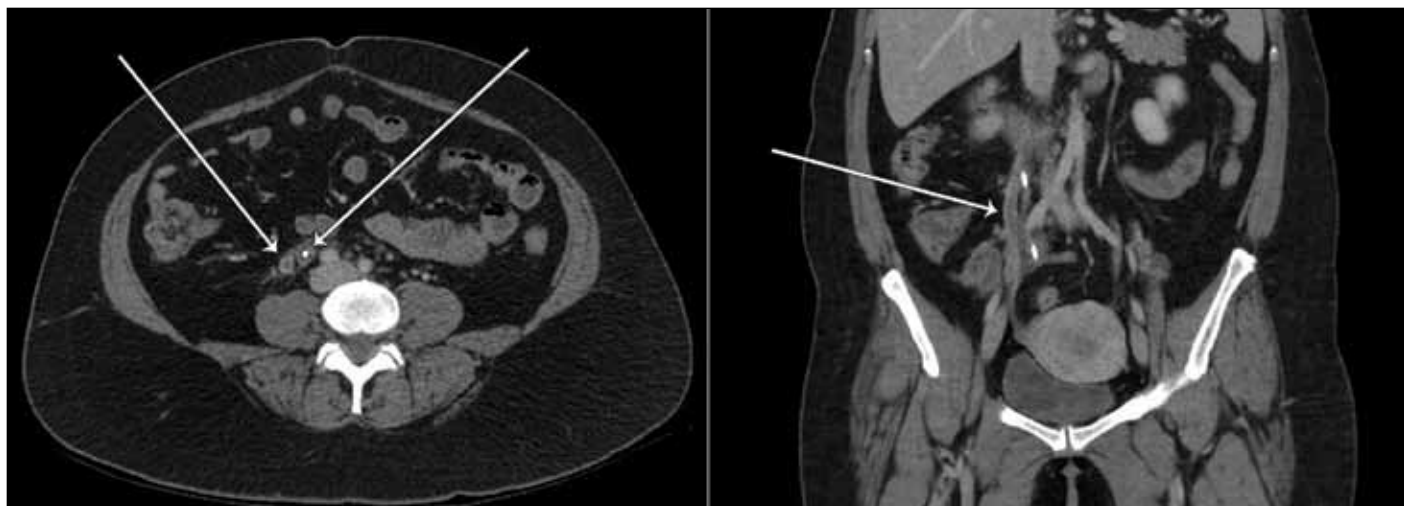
Postoperative computed tomography images showing right ovarian vein thrombosis (arrow) in transverse (*left*) and coronal (*right*) views.
